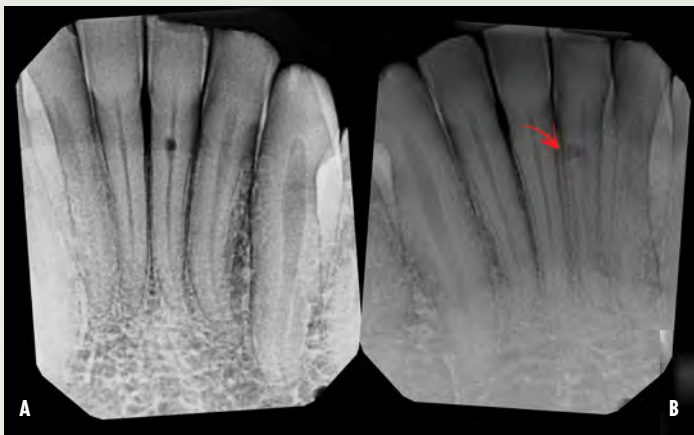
A,B: Two periapical radiographs of tooth #24 taken at different angles. Resorptive defect changes position relative to root canal, which according to buccal object rule means defect is separate from canal and, hence, external to canal.
